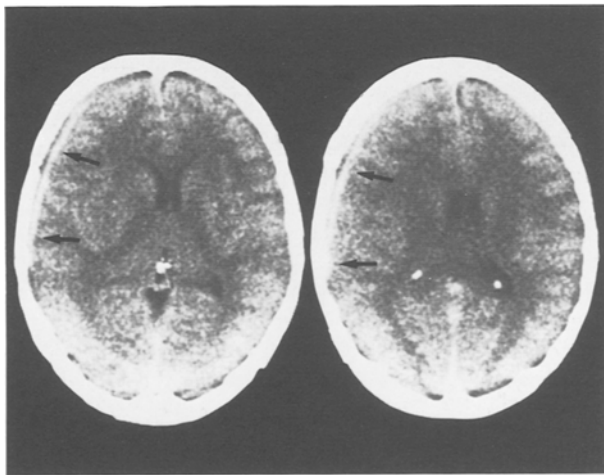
Computed tomography scans 3 days following the onset in case 2, revealing a thin, high density mass over the right cerebral cortex (arrows)
